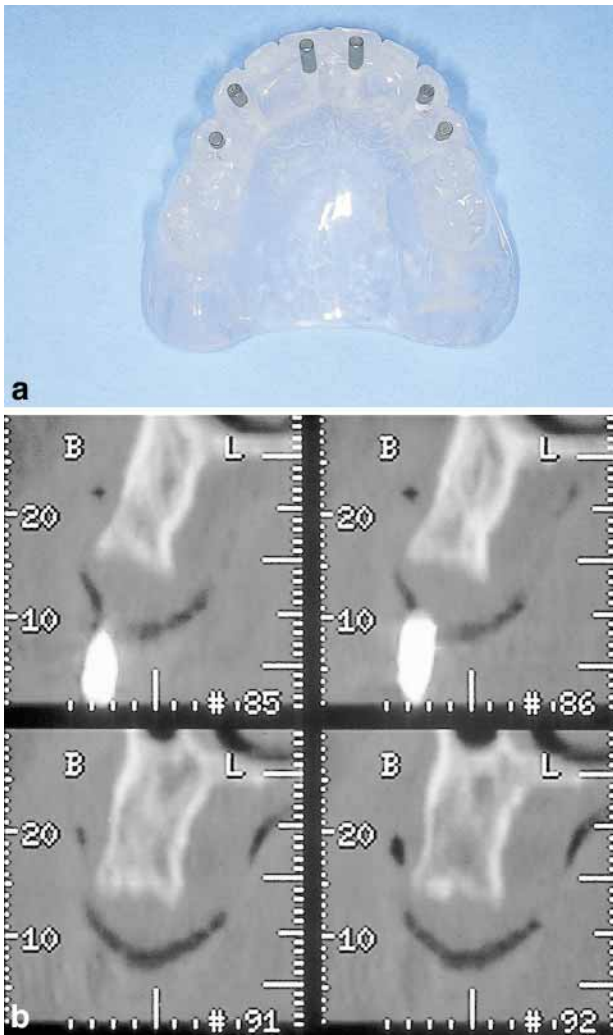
a) Radiographic template: duplication of tooth setup or of a well-fitting existing denture, with titanium pins, indicating tooth position and tooth length. b) CT-scan: pins allow for detailed analysis and measurements.
